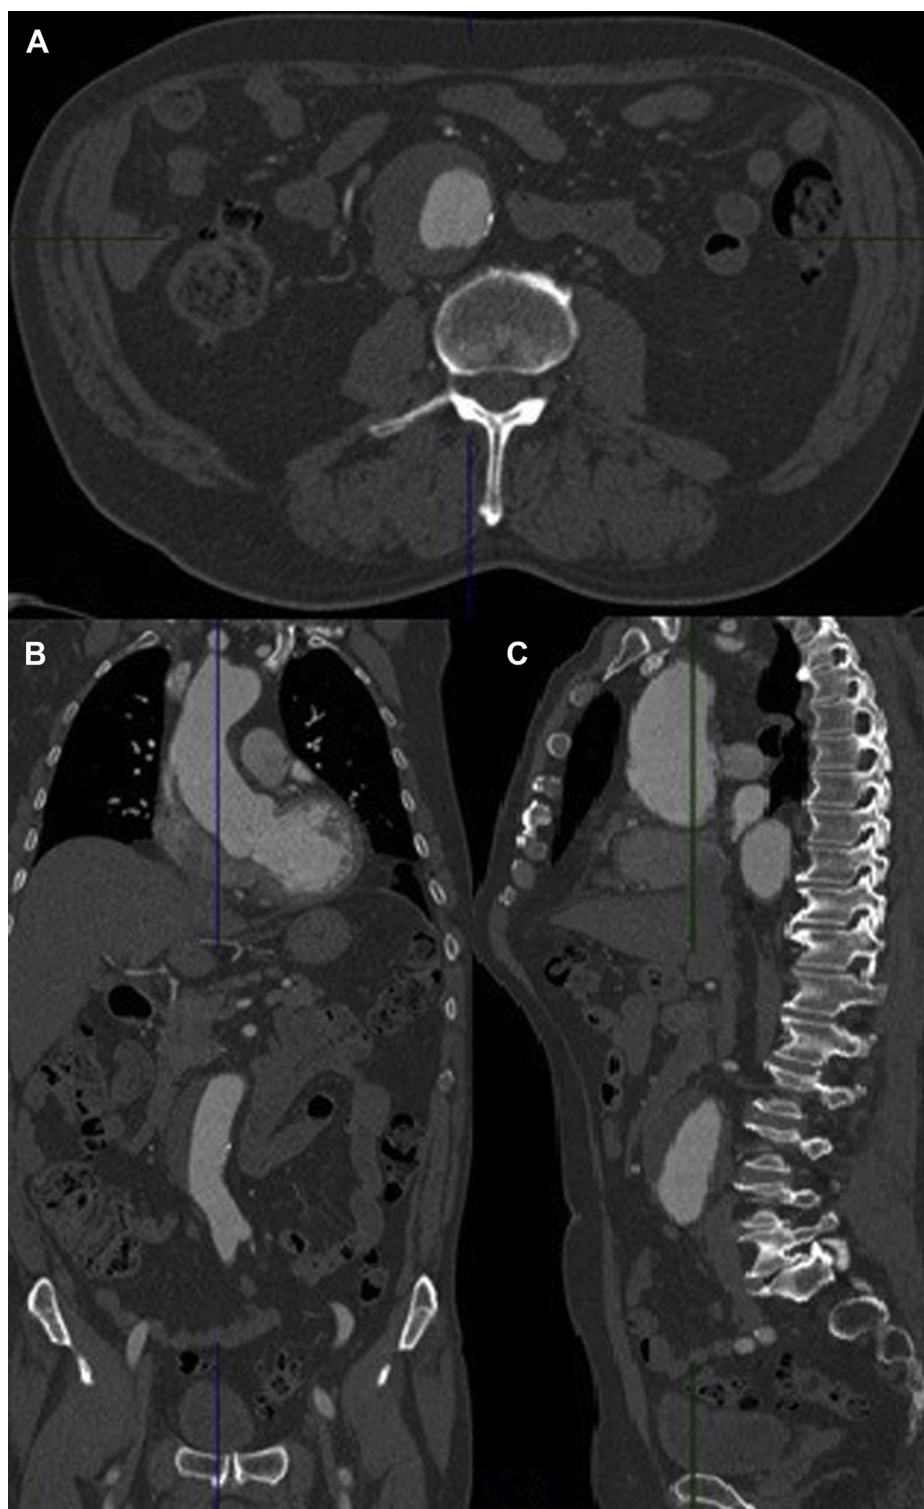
Preoperative computed tomography (CT) angiogram (CTA) in 2012 with innocent looking homogenous thrombus within the abdominal aortic aneurysm (AAA) and no alarming findings in the aortic sac or periaortic tissue (A) CTA axial view, documenting AAA with thrombus and no alarming findings in the aortic sac. B, CTA coronal view, documenting AAA with thrombus along the lateral aortic wall, the thrombus appears homogenous without any suspicion of any abnormality. C, CTA sagittal view, documenting AAA with thrombus along the anterior and posterior aortic wall, the thrombus seems to be homogenous without any suspicion of any abnormality.
